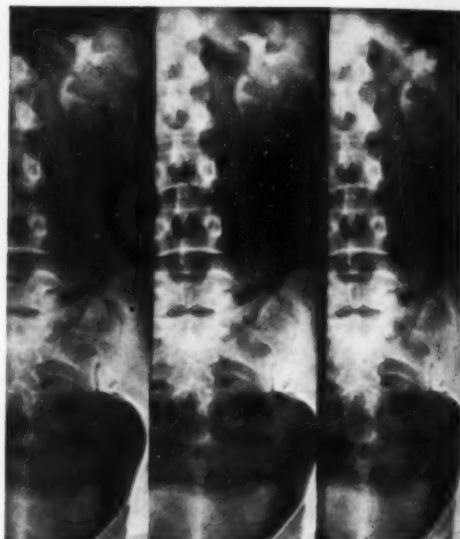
Serial exposures of the urinary tract on one side. In the roentgenograms, one can demonstrate physiological changes when present, as concerned with the size and shape of the calices and pelvis. The various portions of the ureter can be recorded if it contains dye.
